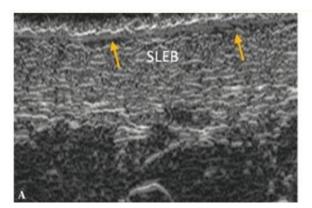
Ultrasound image of the dermis with visible division into upper and lower layers
